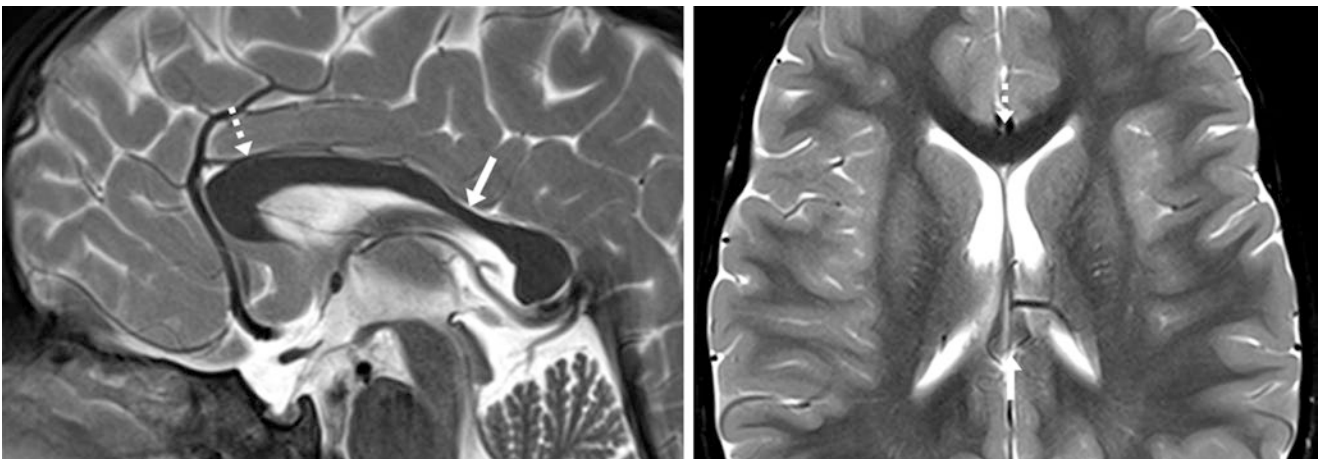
A 3 year old with an otherwise negative 3T MRI obtained for seizures that demonstrated a normal, moderately thin callosal isthmus (arrows) on a midline sagittal T2WI (*left*). An axial T2WI through the level of the isthmus (*right*) confirmed the disparate thickness of the callosal isthmus relative to the anterior body (dashed arrows)
